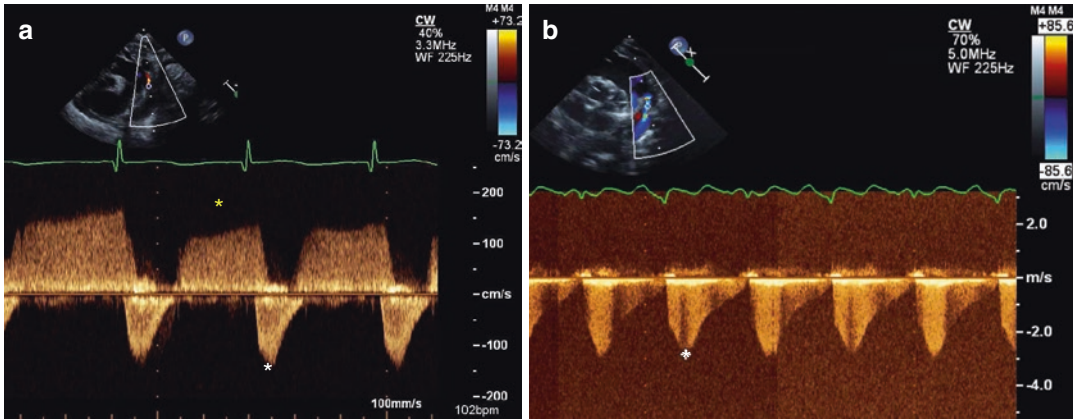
PDA Doppler. (a) Bidirectional PDA shunt with flow above (yellow star) and below the baseline; (b) Pure right to left flow (white star) across the PDA consistent with suprasystemic pulmonary pressures
